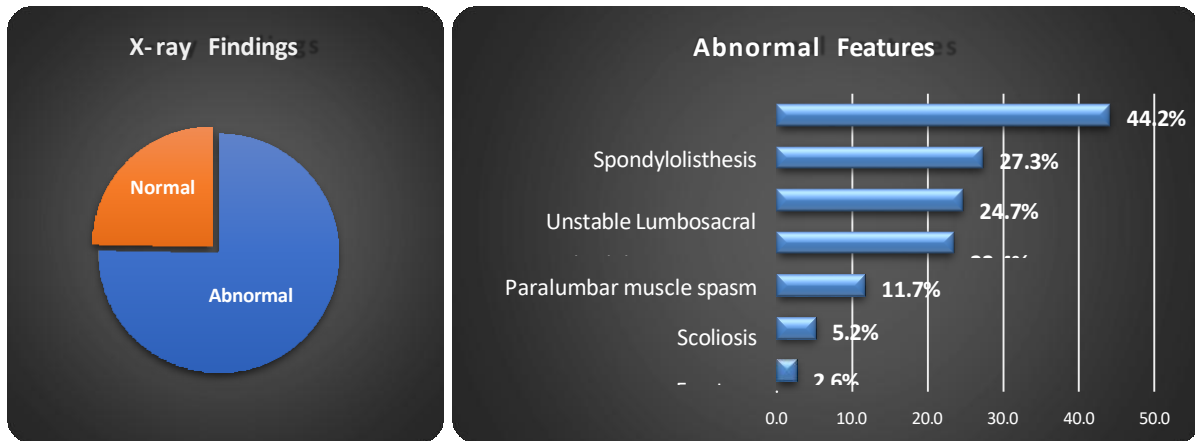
Plain lumbosacral X-ray findings for LBP
